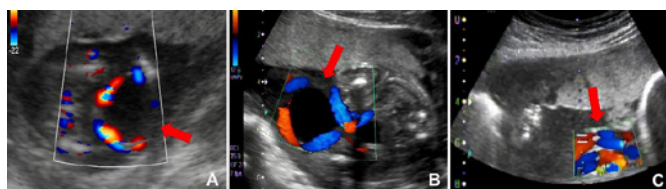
Two-dimensional ultrasound images using Doppler, showing the allantoic cyst (red arrows) at 16 weeks and 2 days (A), and at 21 weeks and 2 days (B). Note that at 24 weeks and 2 days, the cyst was no longer visible, and there was a coiling of the umbilical cord near the abdominal wall (red arrow) (C).
